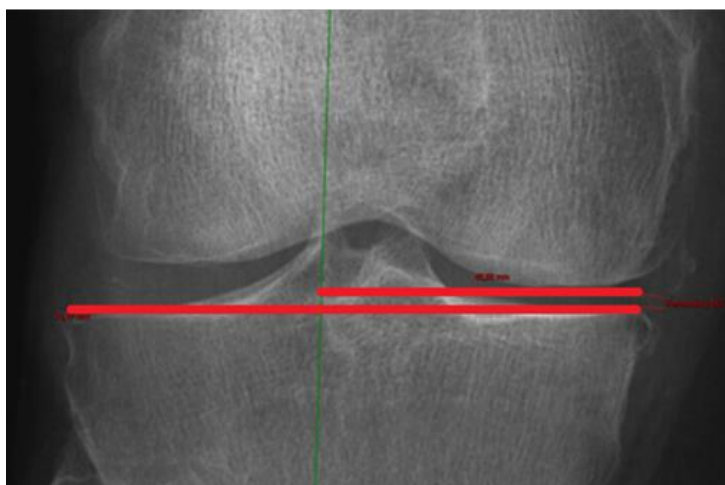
Two-dimensional (2D) lateral tibial spine ratio measurements (red lines) on full-leg standing radiographs (FLSR). Medial corresponds to 0%.
